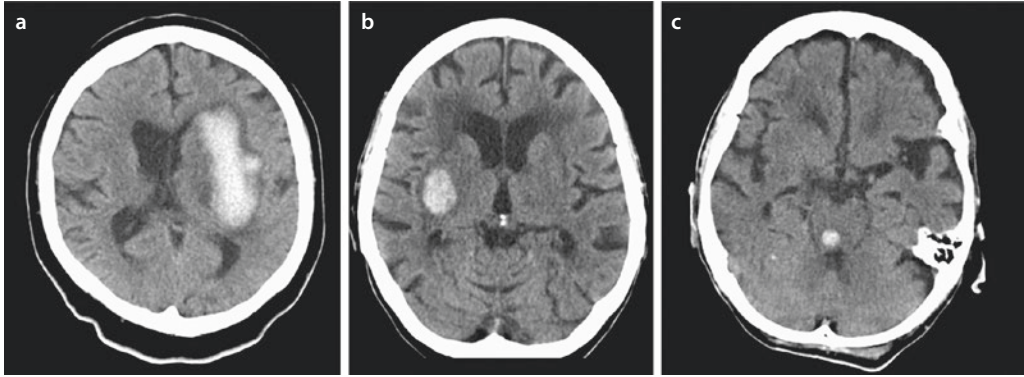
Intracerebral hemorrhage on CT. a Basal ganglia on left. b Basal ganglia on right. c Pons
